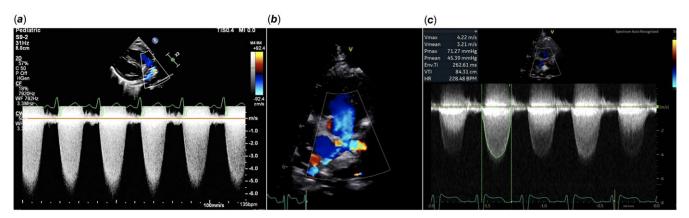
Transthoracic echocardiogram performed for patient 1. (a) Pre-balloon angioplasty Doppler of IPAB with peak velocity > 5 m/sec. (b) Parasternal short axis view with colour Doppler performed the day following balloon angioplasty of IPAB. (c) Post-balloon angioplasty Doppler with peak velocity 4.2 m/sec. IPAB = internal or intraluminal pulmonary artery banding.
